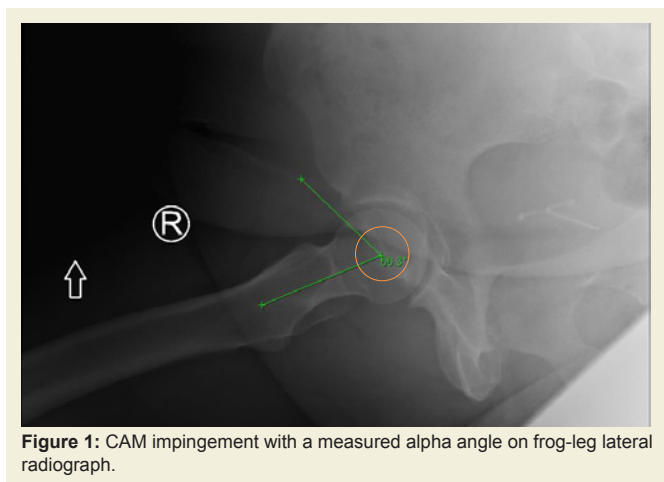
CAM impingement with a measured alpha angle on frog-leg lateral radiograph.
